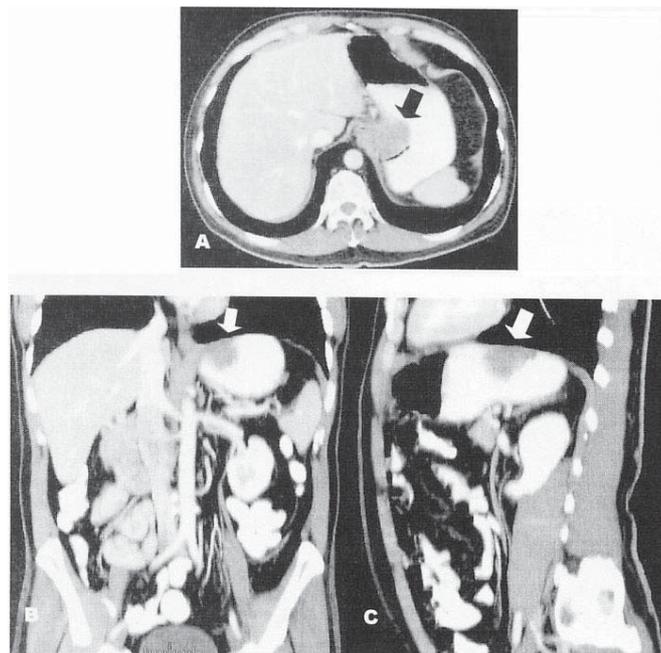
A solid, homogeneous and polypoid lesion (arrows). Lesions shown in the cardia in axial section (A) of multislice CT, with coronal (B) and sagittal (C) reconstructions
